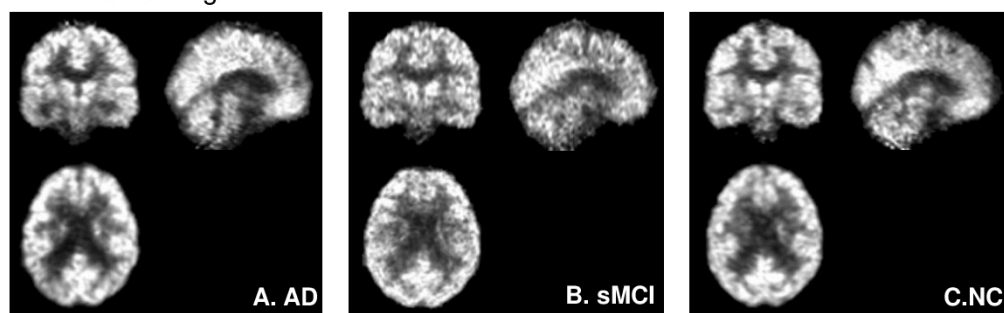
Example preprocessed FDG PET scans from (A) a patient diagnosed with AD, (B) a patient diagnosed with MCI, and (C) a normal control patient.
